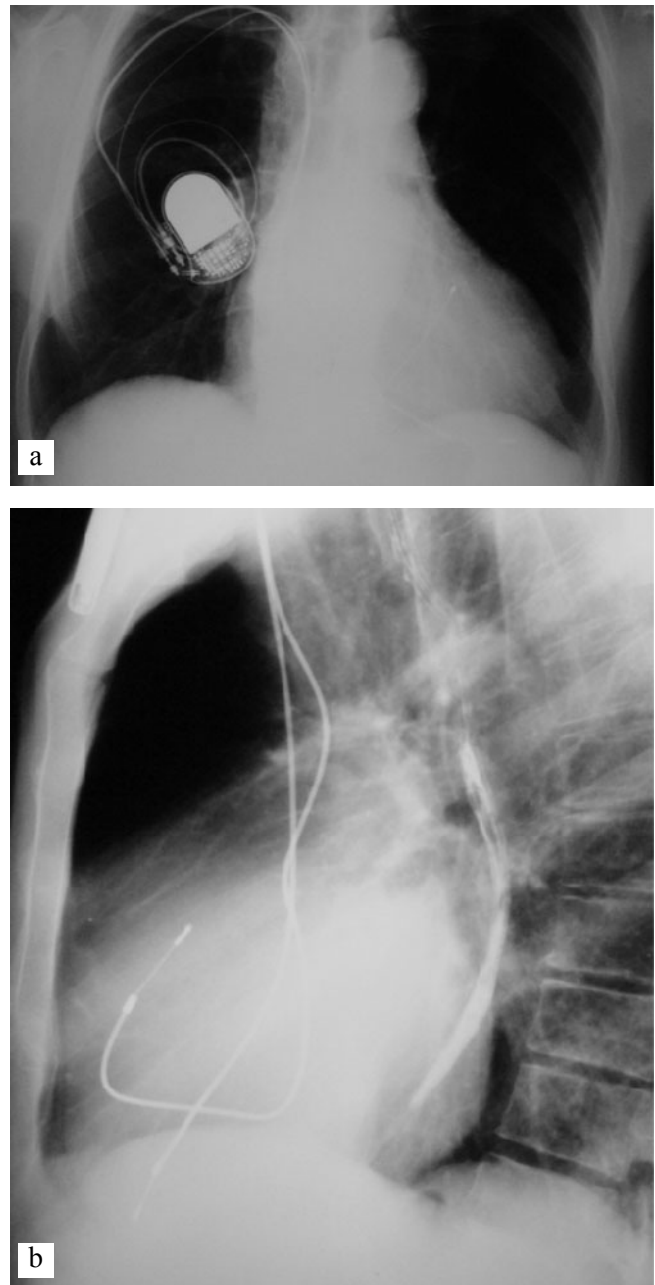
Thoracic X-rays showing the leads implanted in the right ventricle near the outflow tract (panel a) and in the apex (panel b).
